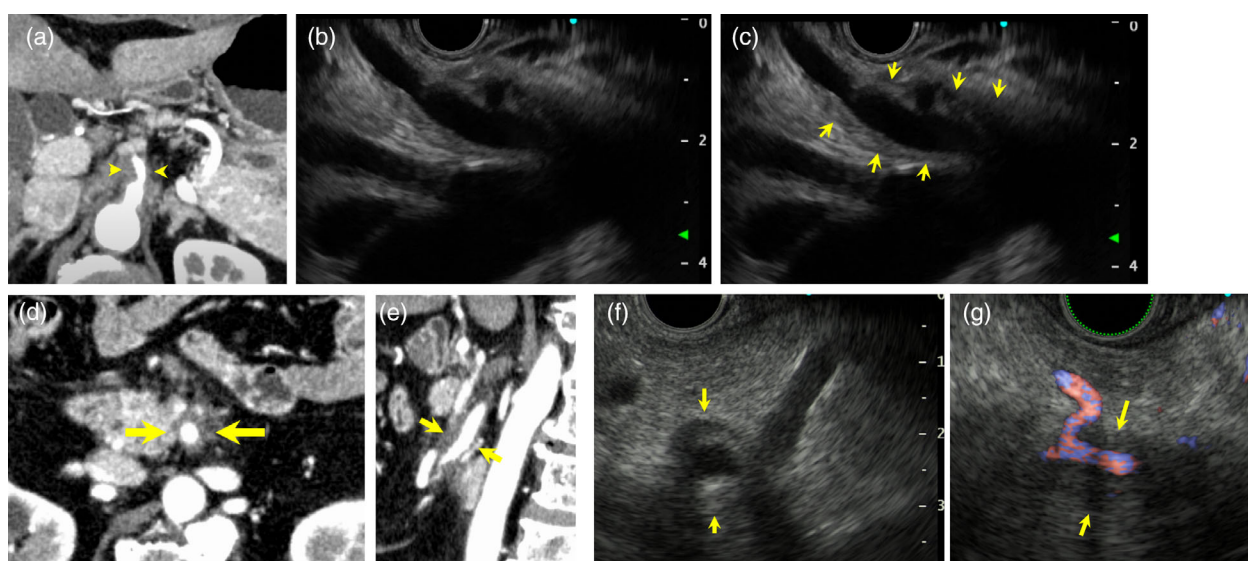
Perivascular soft-tissue cuffing. (a–c) In a patient at celiac artery (arrowhead), (d–g) in a patient at superior mesenteric artery. (a) On computed tomography (b,c) on endoscopic ultrasound, (d,e) on computed tomography, (f,g) on endoscopic ultrasound, perivascular soft-tissue cuffing (arrow).
